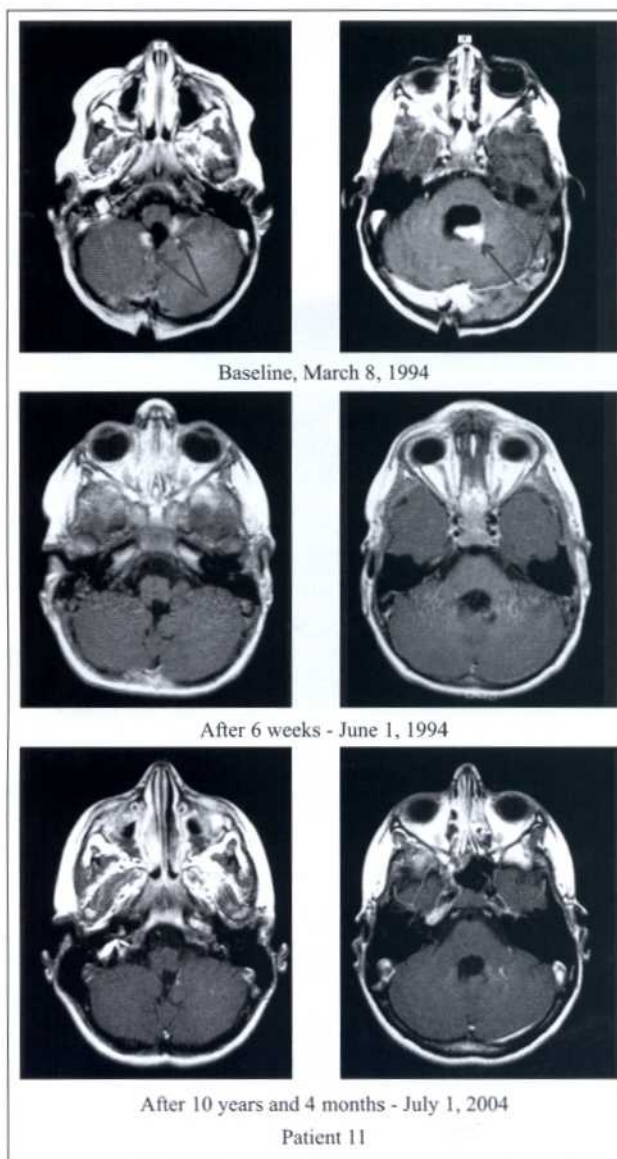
Successful treatment of a 2-year-old male diagnosed with medulloblastoma of the cerebellum and brainstem on February 13, 1994 (patient 11). After subtotal resection, the patient did not receive radiation therapy or chemotherapy. T1-weighted gadolinium magnetic resonance imaging of the head shows disappearance of the tumor size after treatment with antineoplastons. The patient is now alive and well more than 10 years, 4 months since the start of treatment.
